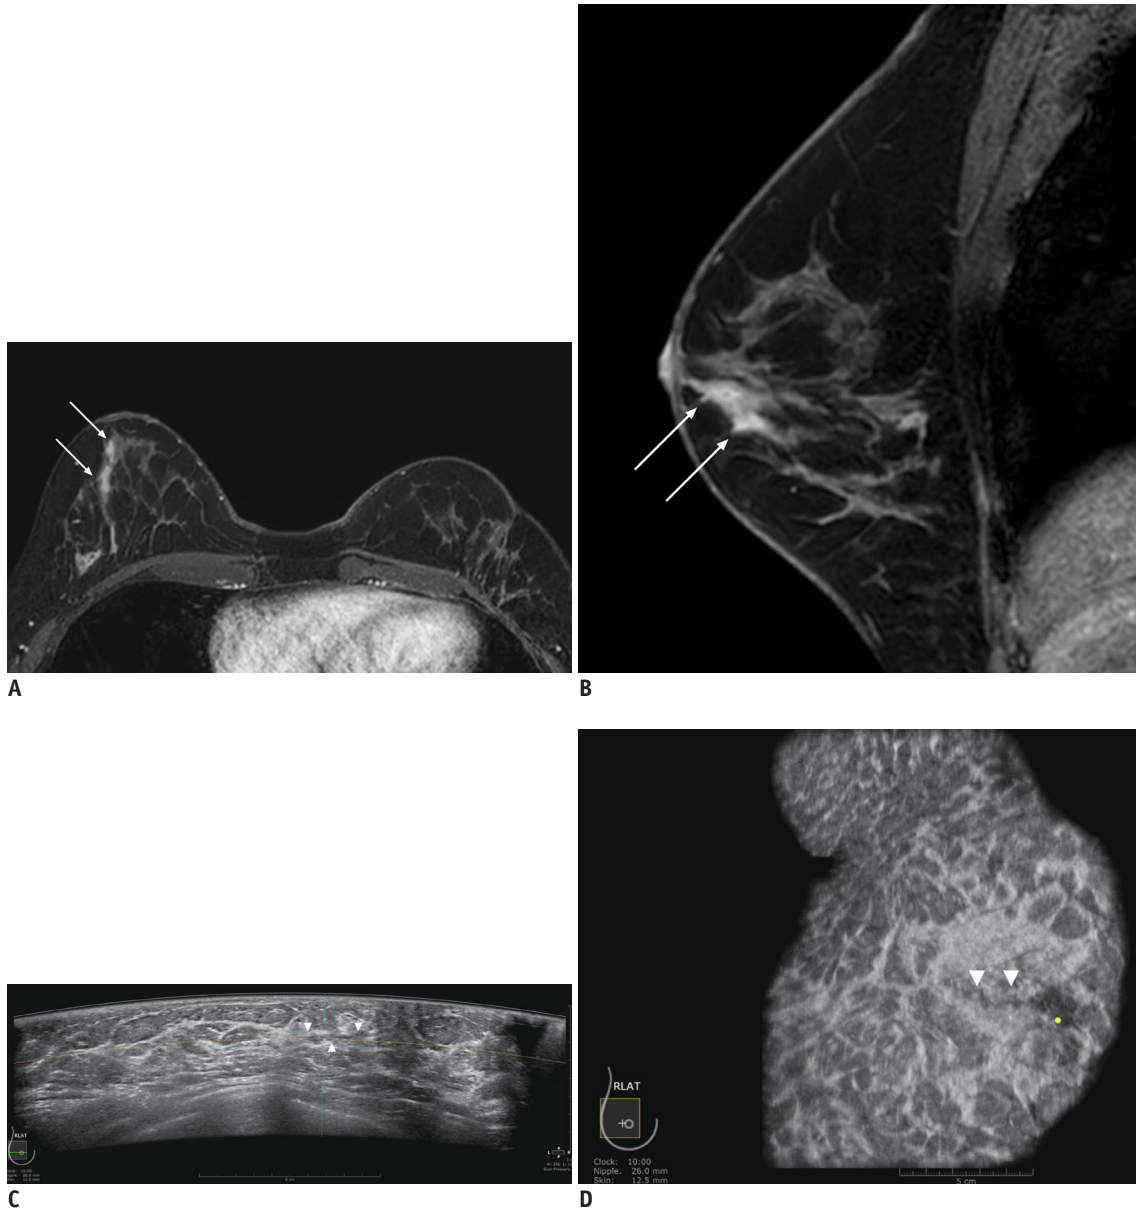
45-year-old female with right breast cancer who underwent MRI and ABUS for preoperative staging. Axial (A) and sagittal (B) dynamic contrast-enhanced MRI show linear, heterogeneous non-mass enhancements (arrows) at right outer subareolar region. ABUS images show ill-defined, indistinct lesion (arrowheads) on axial (C) and coronal (D) planes of right breast. Lesion measured 1.7 cm on ABUS and 2.8 cm on MRI. Mass was classified as BI-RADS category 4A. This patient subsequently underwent US-guided biopsy, and confirmed to usual ductal hyperplasia.
